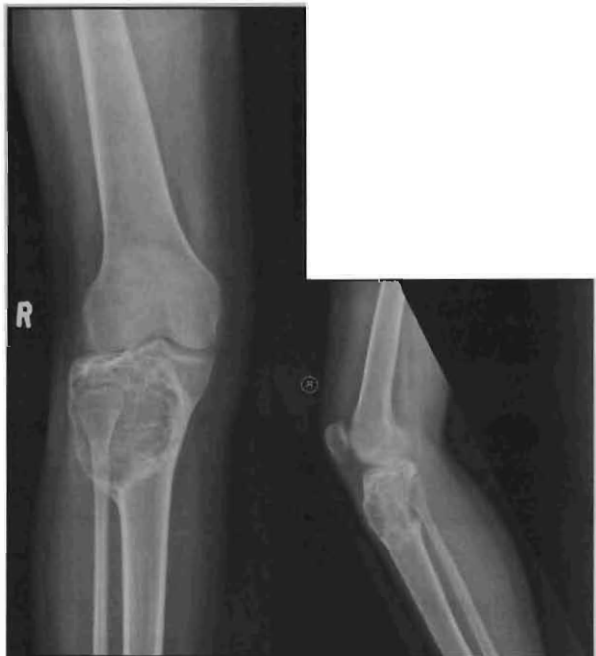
Frontal and lateral X-ray views demonstrating an expansile, 'soap bubble'-like lesion in the proximal right tibia. The lesion appears to demonstrate imaging findings suspicious of partial posterior cortical erosion.
